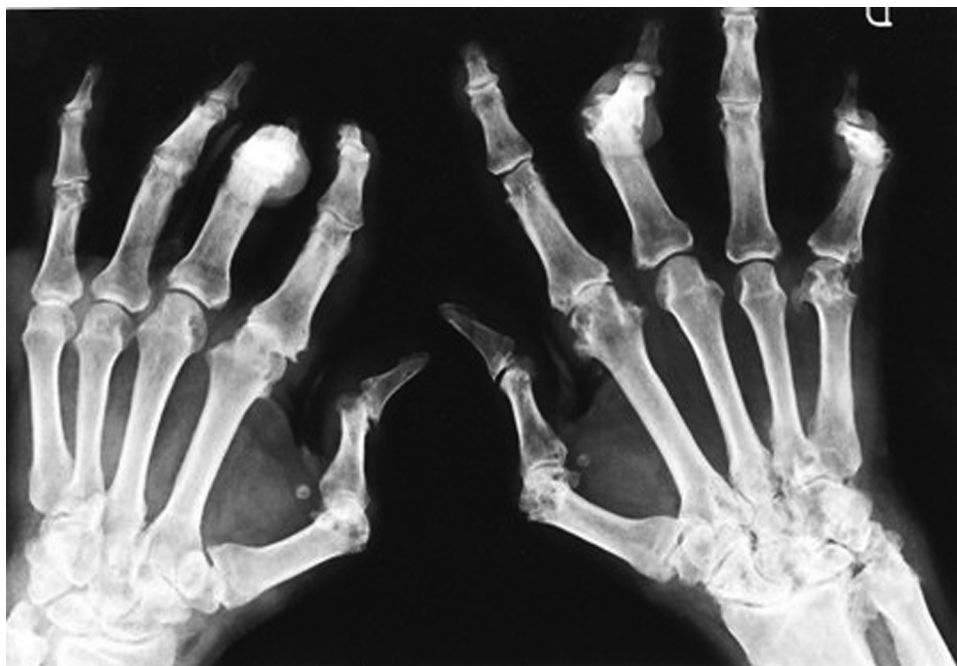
Hands radiography revealing exuberant joint destruction in carpal and proximal interphalangeal joints, juxta-articular new bone formation and enthesitis.
